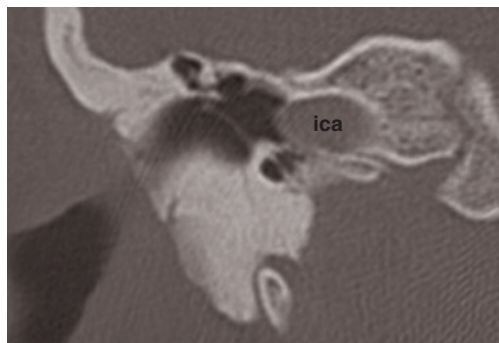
Coronal CT scan. Protrusion of the internal carotid artery (ica) into the middle ear (reproduced from Calzolari F., 2006,⁶ with permission of Omega Edizioni).
